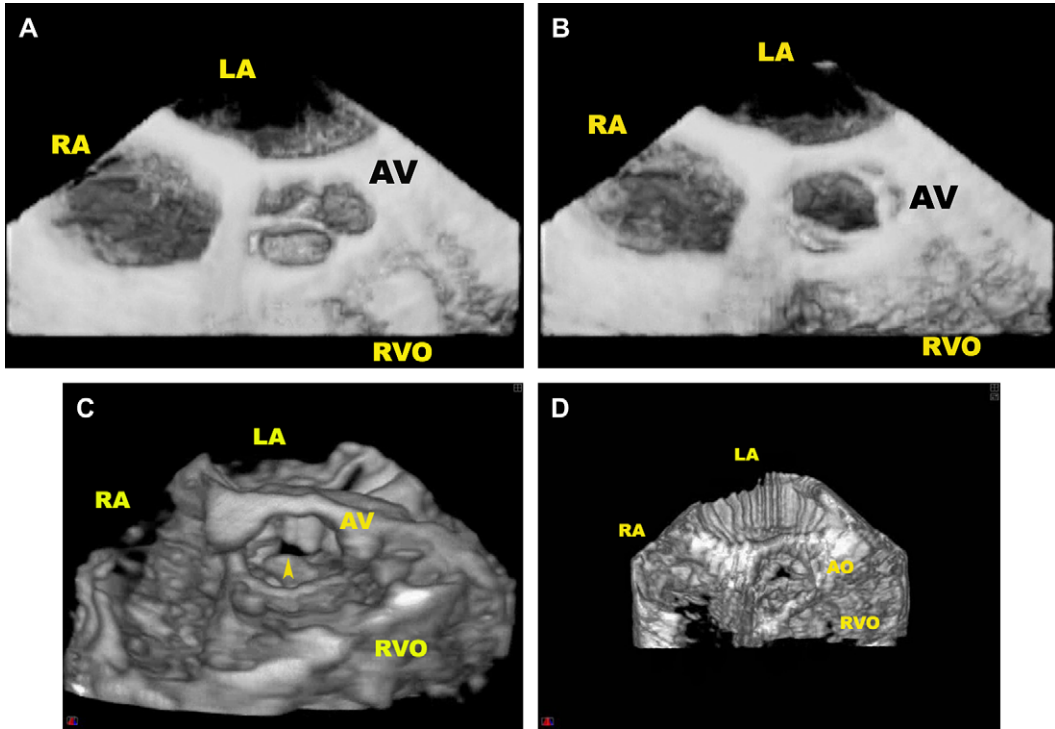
3D transesophageal echocardiographic reconstruction in aortic valve stenosis. Thickened bicuspid aortic valve without significant stenosis, shown in the closed (A) and open (B) positions. (C) Severe, calcified bicuspid aortic valve stenosis. Note the transversely oriented very small aortic orifice (arrowhead). (D) Another patient with calcific severe stenosis. Note that despite severe calcification, the tricuspid morphology of the valve is evident. *Abbreviations:* AO, aorta; RA, right atrium; RVO, right ventricular outflow tract. (Reproduced from Dod HS, Nanda NC, Baweja G, et al. Three-dimensional transesophageal echocardiographic assessment of aortic valve pathology. *Am J Geriatric Cardiology* 2003;12:209–13; with permission.)
